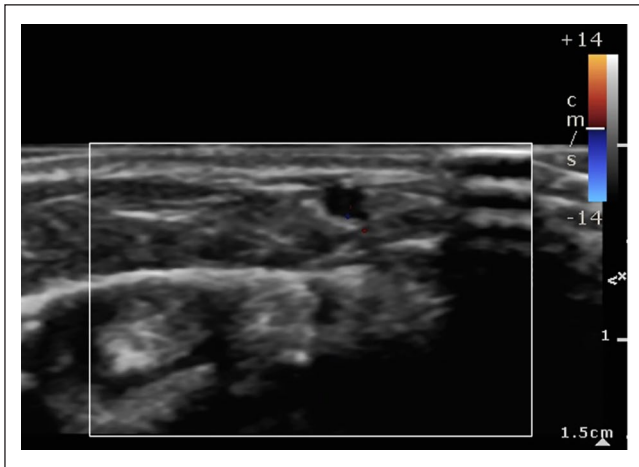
Basilic vein with color flow Doppler imaging during saline infusion. No flow is visualized indicating proximal infiltration.
